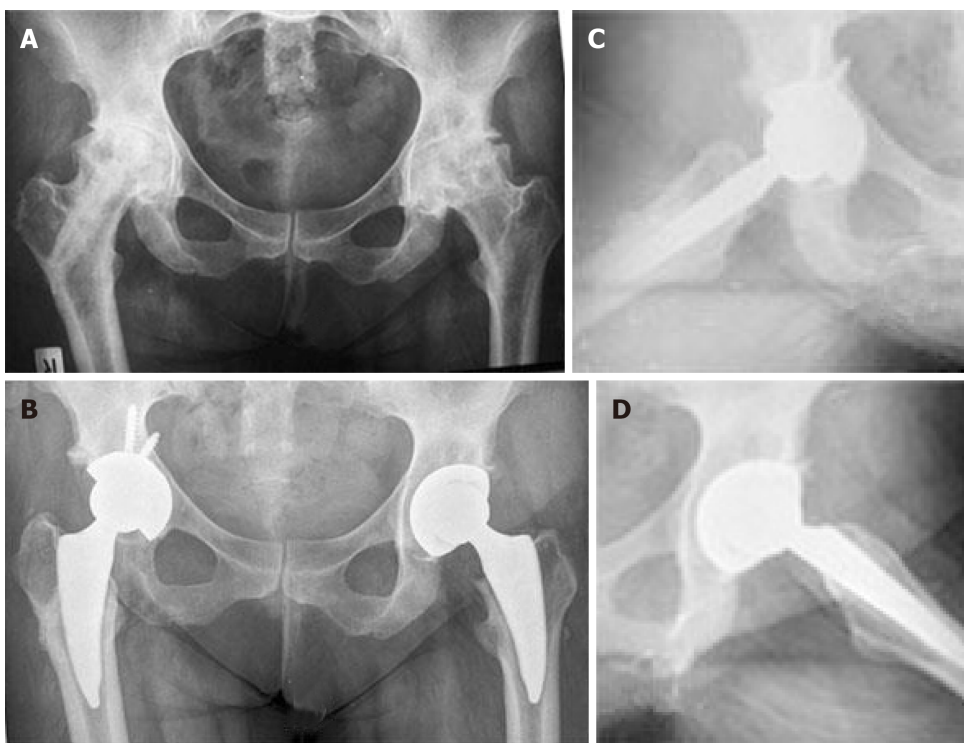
Bilateral osteonecrosis in a 24 years female patient suffered from lymphoma. A: Patient treated on the right side with a vascularized fibular graft; B: Postoperative radiographs 4 years postoperatively on the right side; C: 3 years on the left side; D: Lateral radiographs.
